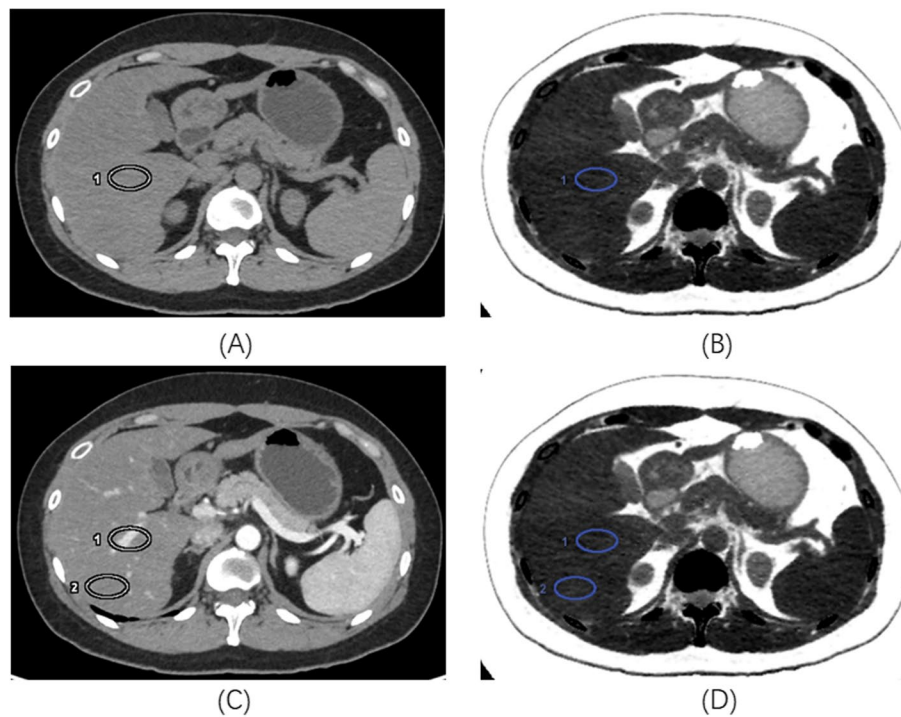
The CT images from a young man with NAFLD. A 400 mm.² ROI (ROI1) was placed on the RPL on 70 keV NCP image (A) without the reference of enhanced CT images, and the FVF value was measured as 15.51% on the corresponding fat image (B). Another ROI (ROI2) was carefully placed avoiding the blood vessel according to the enhanced 70 keV PVP images (C), and the FVF value was measured as 16.94% on the corresponding fat image (D). Note: FVF fat volume fraction, NAFLD nonalcoholic fatty liver disease, NCP non-contrast enhanced phase, RPL right posterior lobe
